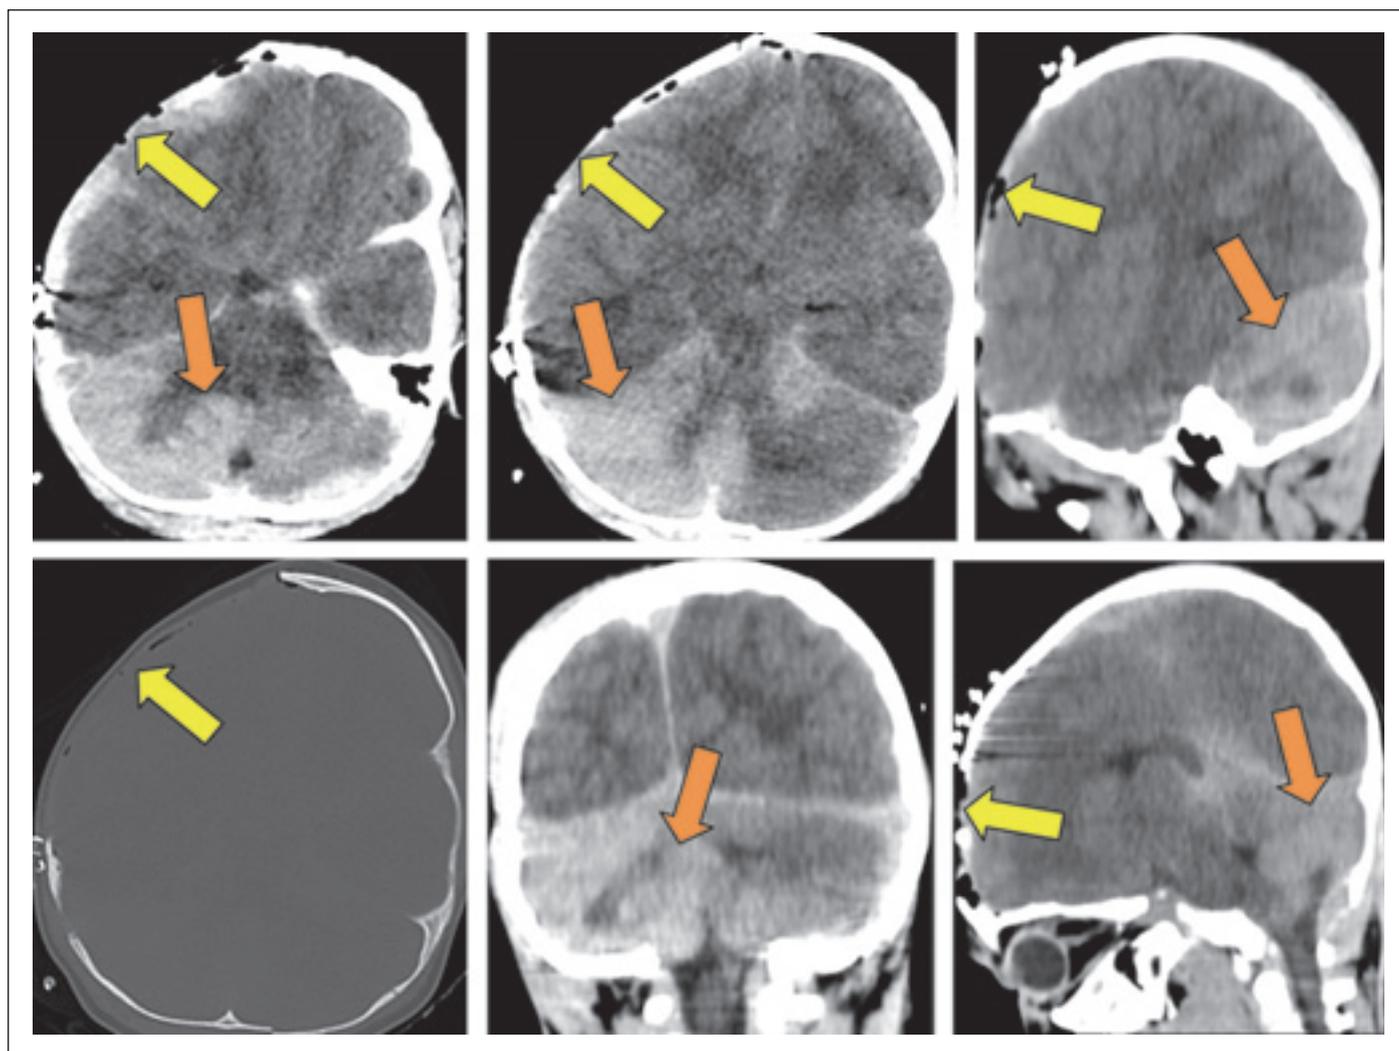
Post-operative CT images demonstrating the white cerebellum sign. The upper row shows brain (tissue) window images, with axial sections in the first and second panels and a sagittal section in the third panel. The lower row includes an axial bone window image in the first panel, followed by coronal and sagittal brain (tissue) window images in the second and third panels, respectively. The yellow arrow indicates the decompression area, while the orange arrow highlights the diffuse hyperdensity in the infratentorial region.
